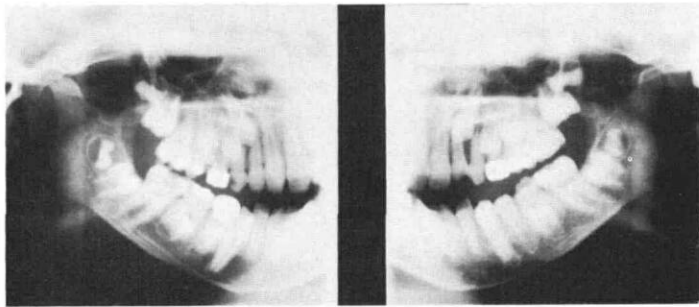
A panoramic radiograph of a 10-year-old child with JRA. The right condylar head shows significant erosion due to the disease.
